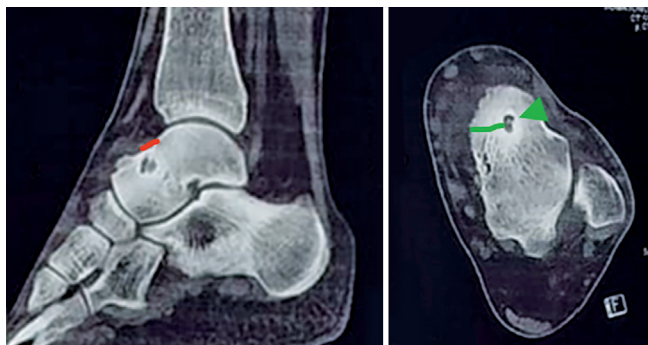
Computed tomography scan showing an anterior osteophyte with an osteoid osteoma nidus in the talar neck with surrounding sclerosis. Nidus localization: 6 mm from the talar cartilage and 1 cm from the medial talar neck, as indicated by the red line, green line, and green arrow.
